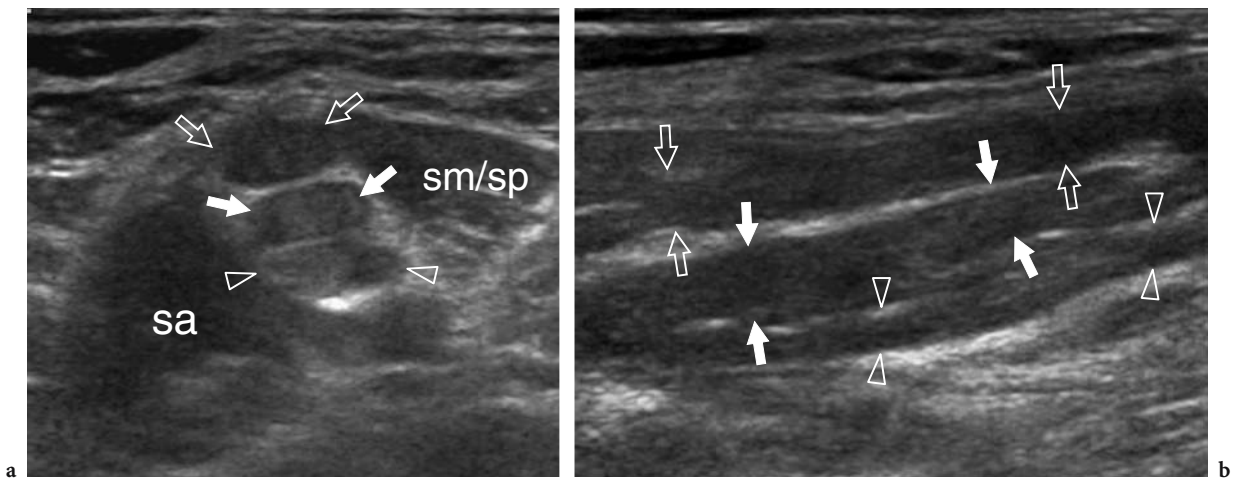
Stretching injury (burner/stinger syndrome) of the brachial plexus nerves in a 25-year-old rugby player with persistent tingling radiating from the left shoulder to the hand and progressive weakness of the limb muscles after a significant contact injury. a Short-axis and b long-axis 12–5 MHz US images over the interscalene area demonstrate segmental thickening of the C5 (*open arrows*), C6 (*white arrows*), and C7 (*arrowheads*) components of the plexus (upper and middle trunks), reflecting fusiform neuromas related to stretching trauma. *sa*, scalenus anterior; *sm/sp*, scalenus medius/scalenus posterior muscles. In the burner/stinger syndrome, MR imaging of the cervical spine should always be performed to rule out nerve damage inside the spinal canal as well as herniated disks, ligament injuries, facet injuries, and undisplaced fractures
